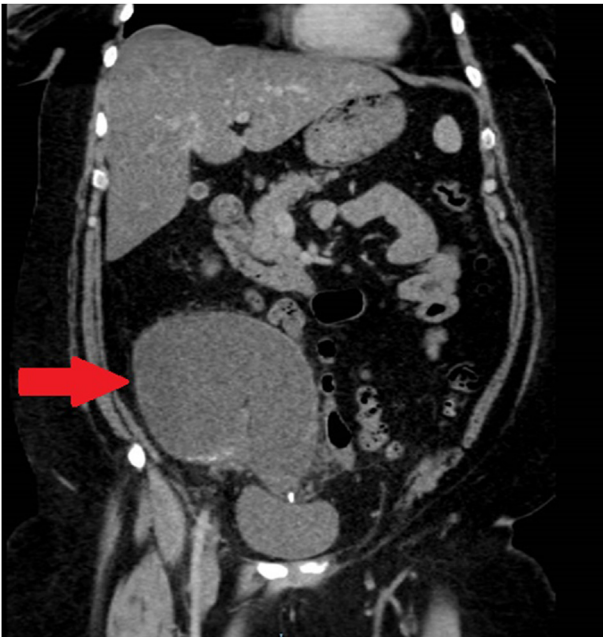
A coronal slice of the computed tomography scan demonstrating the mucocele arising from colonic neovagina.
